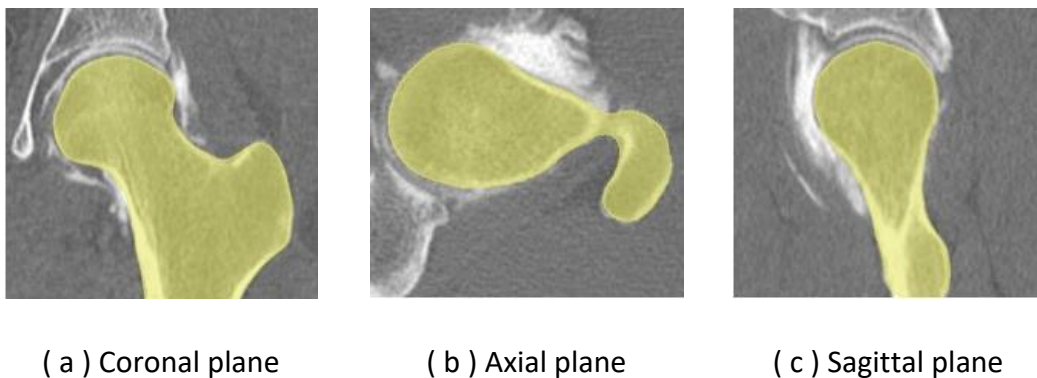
Mask of the proximal femur (yellow) visible in the different planes of the CT scan.
